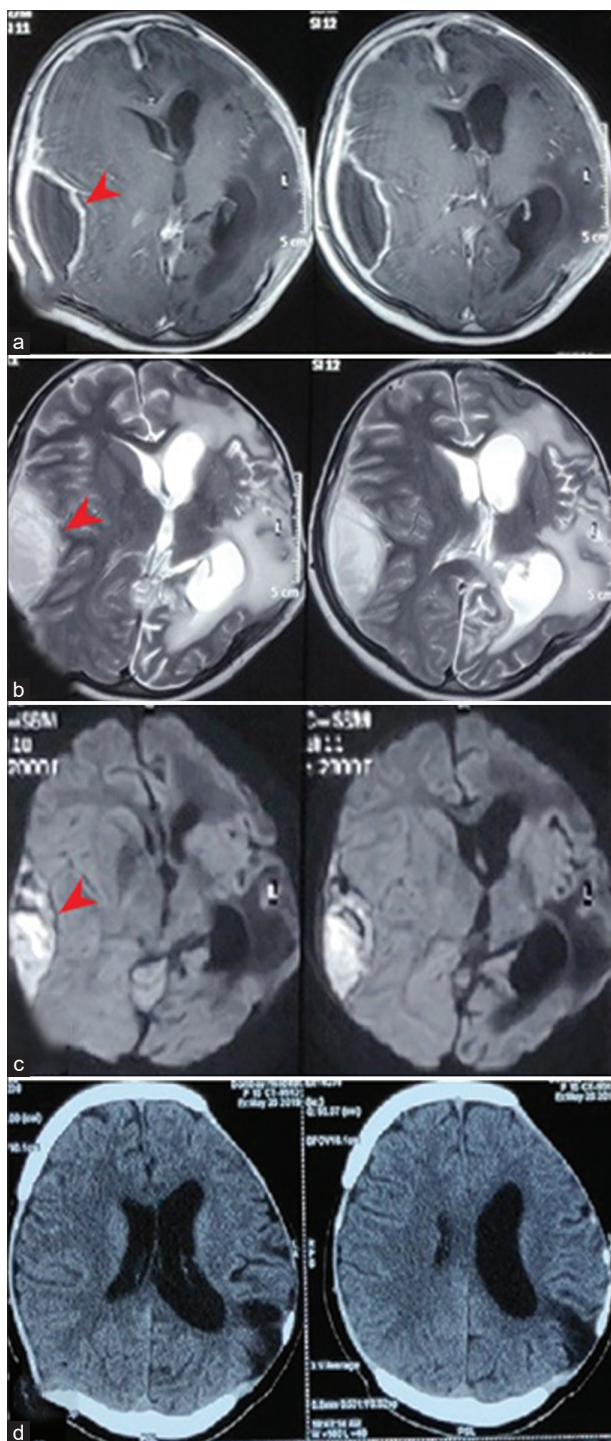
Development of contralateral subdural empyema. (a) Contrast-enhanced magnetic resonance imaging T1-weighted image showing peripherally enhancing collection in the right temporoparietal region with severe mass effect. (b) T2-weighted image showing cystic collection. (c) DWI showing restriction, suggestive of empyema. (d) Post-operative CT scan showing resolution of infective changes, with an area of gliosis in the left parietal region, in the setting of bilateral craniotomy defects
